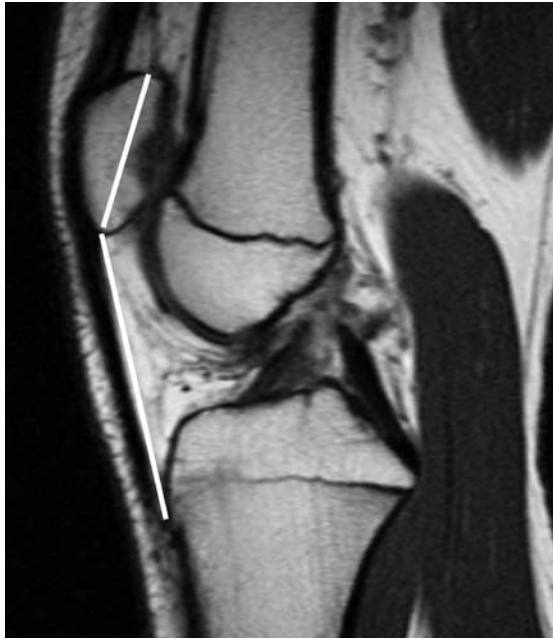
Patella alta in a 27-year-old woman. Sagittal SETI-W MR image of the right knee shows an Insall and Salvati index of 1.7.
